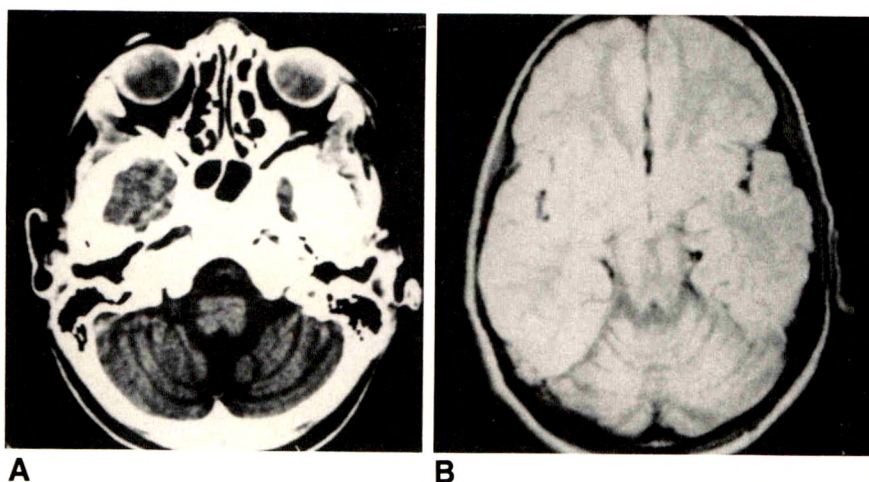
A and B, CT scan (A) and axial MR image (B) obtained 6 months after treatment with high-dose cytosine arabinoside show changes of cerebellar atrophy. Signal intensity on MR image is normal.
